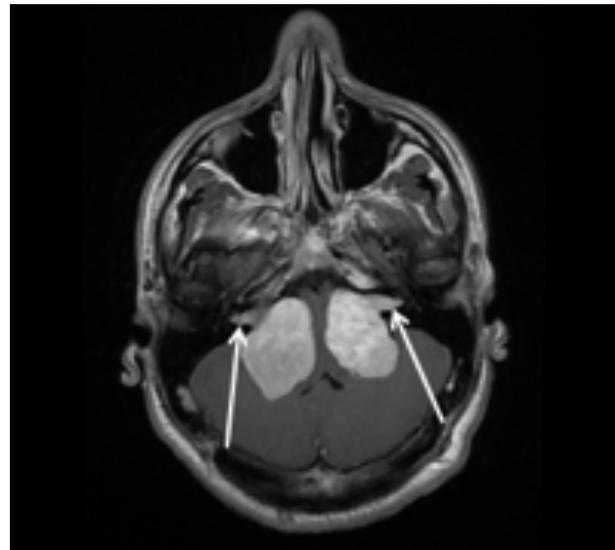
T1 Flair post-contrast MRI at the level of the cerebellum, with arrows indicating bilateral vestibular schwannomas extending into the bilateral internal auditory canals.
